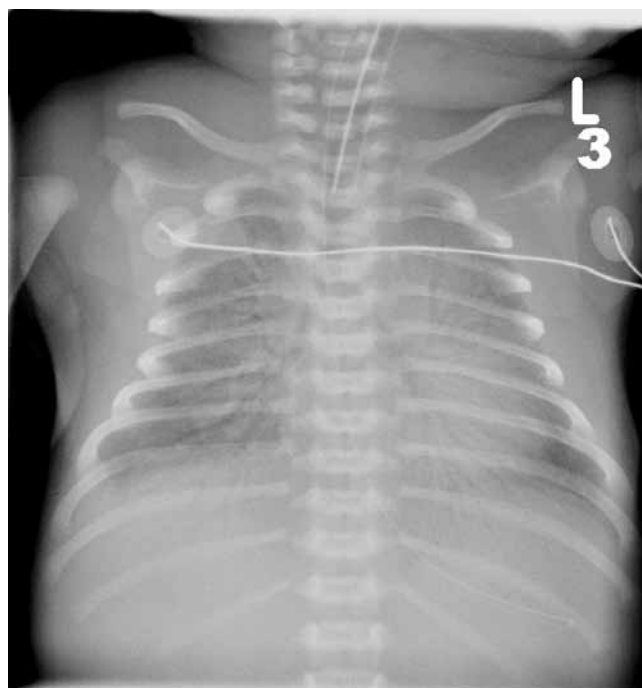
Chest radiograph showing severe RDS
